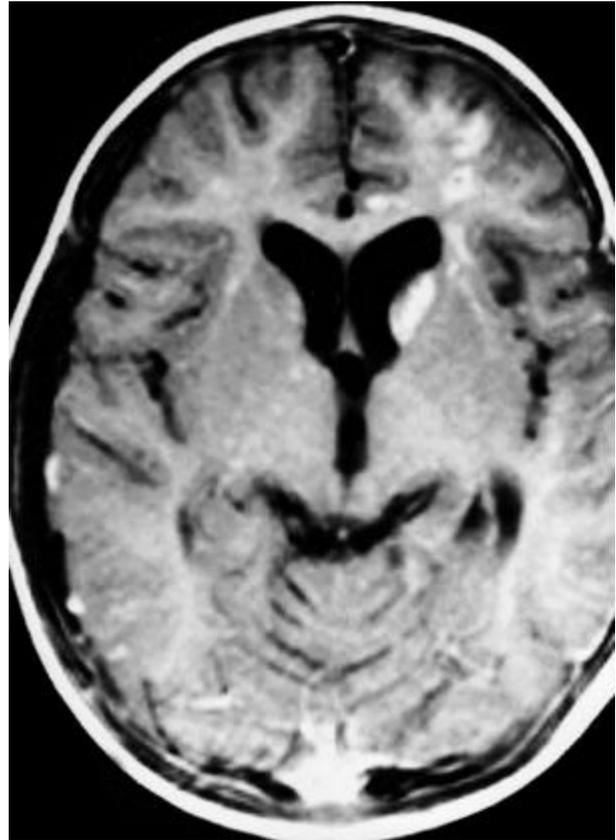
Gd-enhanced T1 weighted axial image (11 days after CT scan) shows well-defined enhanced lesion on the left caudate nucleus head and left frontal lobe, which correspond to the low density in CT scan. A moderate amount of subdural effusion on the right temporoparietal area and moderate dilatation of the ventricular system are demonstrated.
